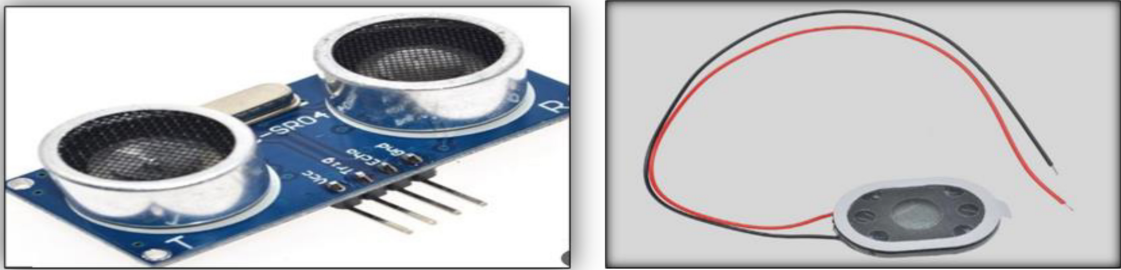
Shows an image of the distance-measuring sensor (HC-SR04 Ultrasonic Sensor).
